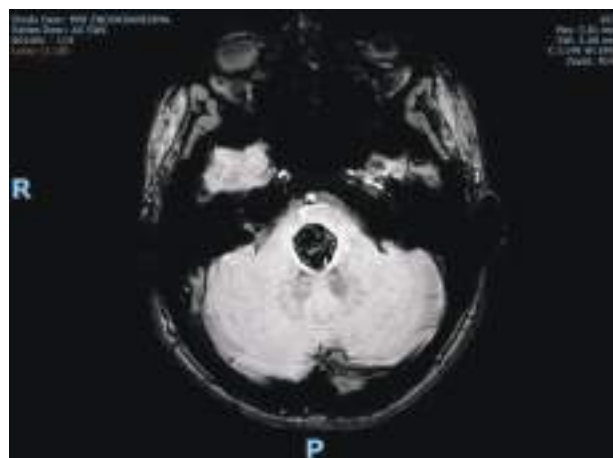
MRI- SWI weighted sequence – first hemorrhage
